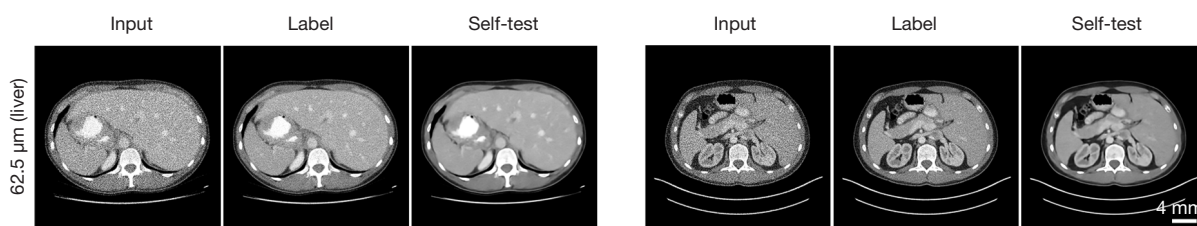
The U-Net self-test results of 62.5 μm CT images (including the images of liver and pancreas). The display window is $[0.17, 0.26] \text{ cm}^{-1}$. The scale-bars denote 4.0 mm. CT, computed tomography.
